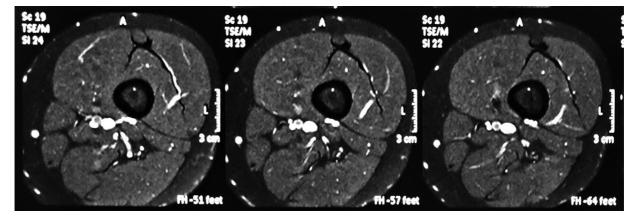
T1-weighted contrast-enhanced MRI 28 months after the surgical treatment, with no signs of local recurrence.
